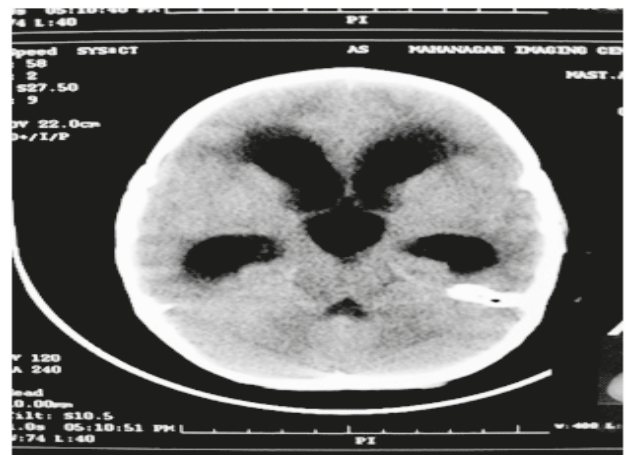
CT Scan of Brain shows hydrocephalus.
